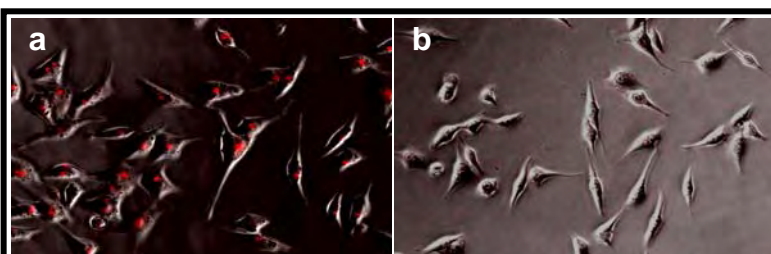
PC3-PSMA cells internalize QDs via clathrin-mediated endocytosis (a). Cells treated with the clathrin inhibitor chlorpromazine do not internalize QDs (b).
